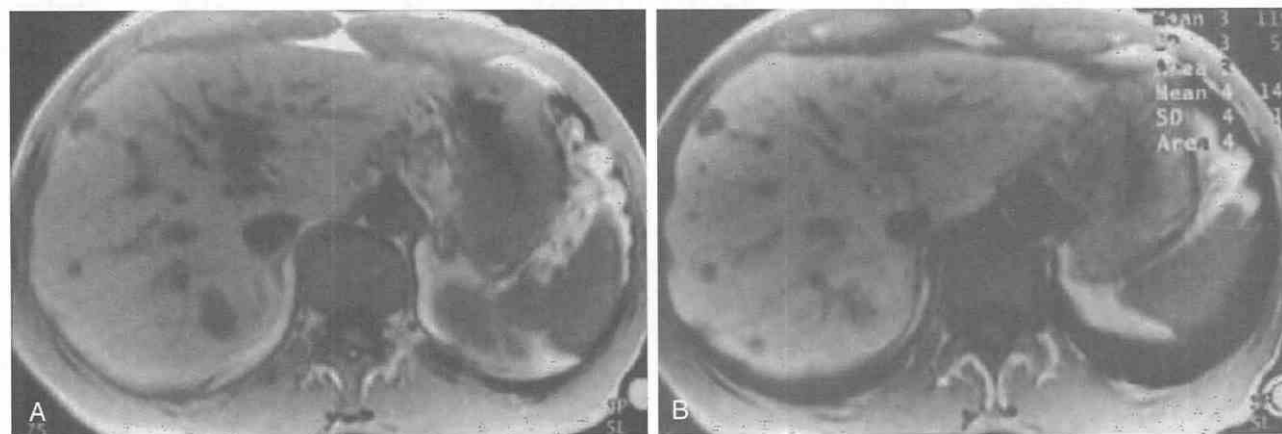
Metastases. *A*, Unenhanced T1-weighted MR image demonstrates multiple hepatic lesions. *B*, T1-weighted MR image after manganese-DPDP administration identified additional lesions.
